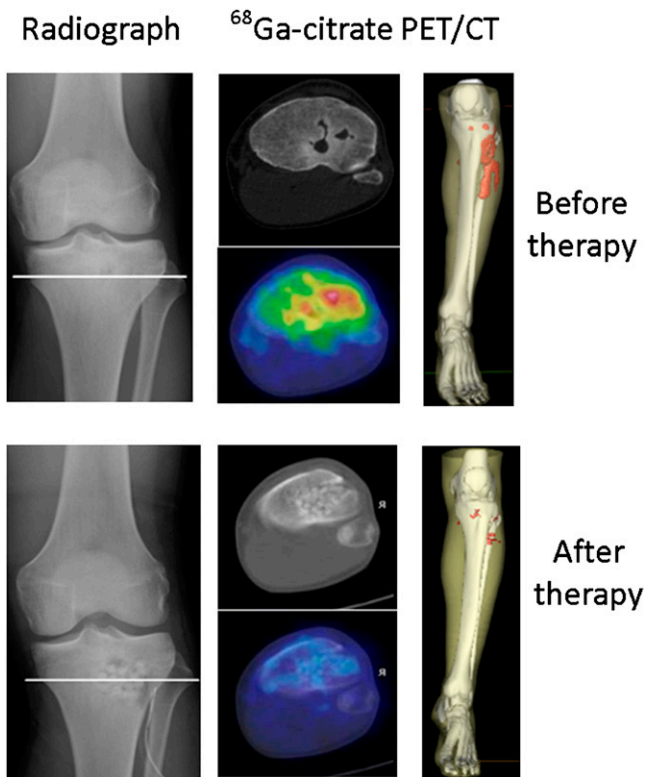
Comparison of ^{68}Ga -citrate PET/CT before and after surgical curettage in patient affected by acute osteomyelitis. On right, 3-dimensional reconstruction shows bone infection (red area) also involving surrounding soft tissue. After therapy, no uptake is evident, confirming complete response.
